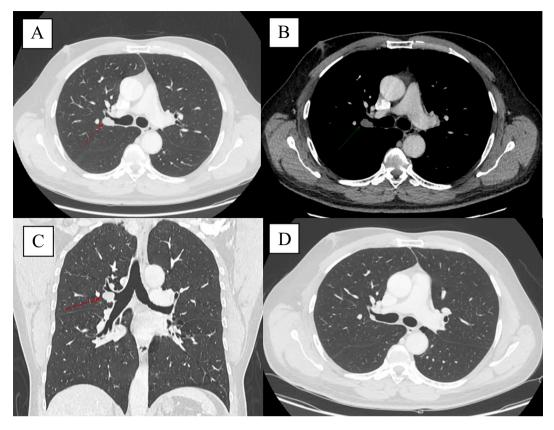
CT chest showing right upper lobe bronchus lobulated lesion with some extension into the adjacent parenchyma. (A, B, C) There is an interval and gradual progression in size versus a previous study (D).
